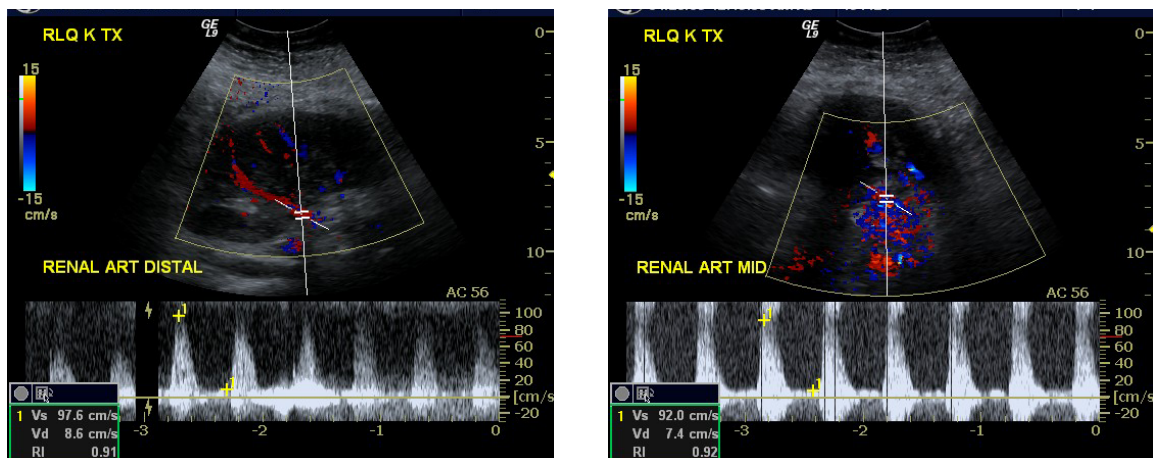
A and B: High resistive index secondary to Acute Tubular necrosis (ATN). Image A, a color and spectral Doppler through the distal transplant renal artery shows normal systolic and low diastolic velocity and an increased resistive index of 0.91. Image B, through the mid renal artery shows similar waveform with a high resistive index.
